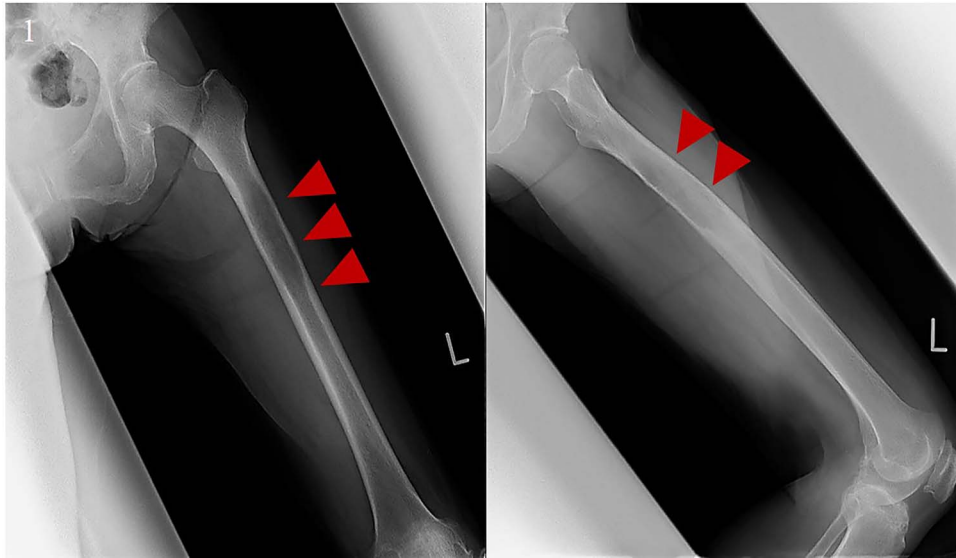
X-ray showed osteolytic lesion in the left femur.
